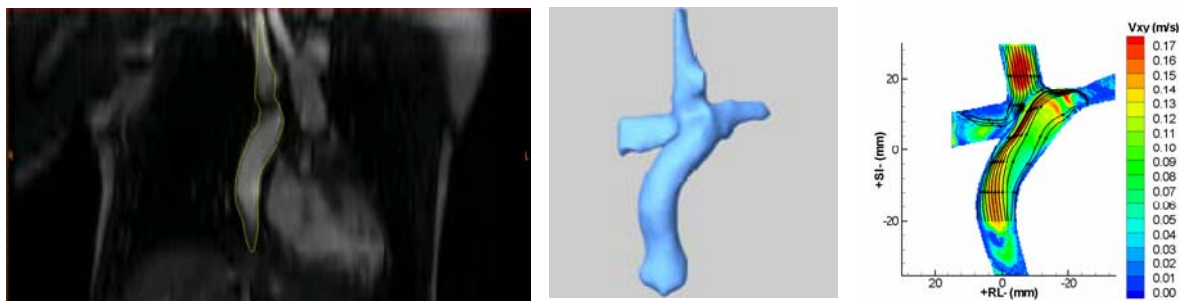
Segmented SVC and IVC on a) MRI and b) 3D anatomic reconstruction of Fontan patient from the coronal perspective. c) PIV TCPC flow field of at a cardiac output of 2 L/min and a 70/30 LPA/RPA flow rate ratio. (Yoganathan et al, 2006)
